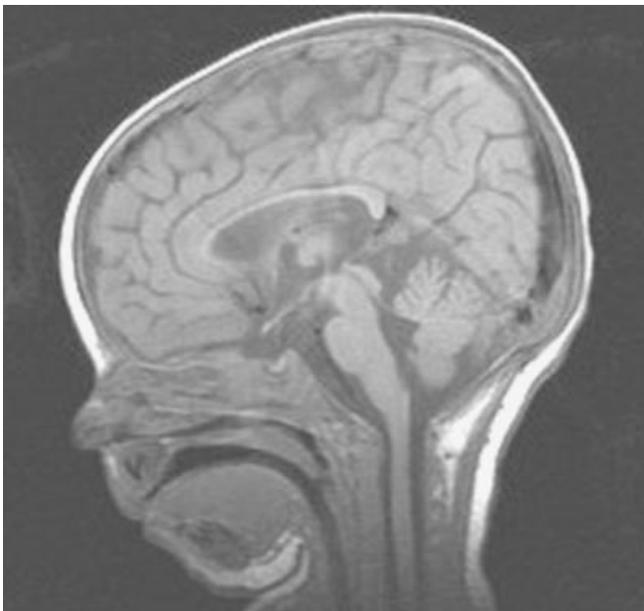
Sagittal MRI image demonstrating increased cerebrospinal fluid spaces, widening of the sulci, delayed myelination, and enlargement of the lateral ventricles.
